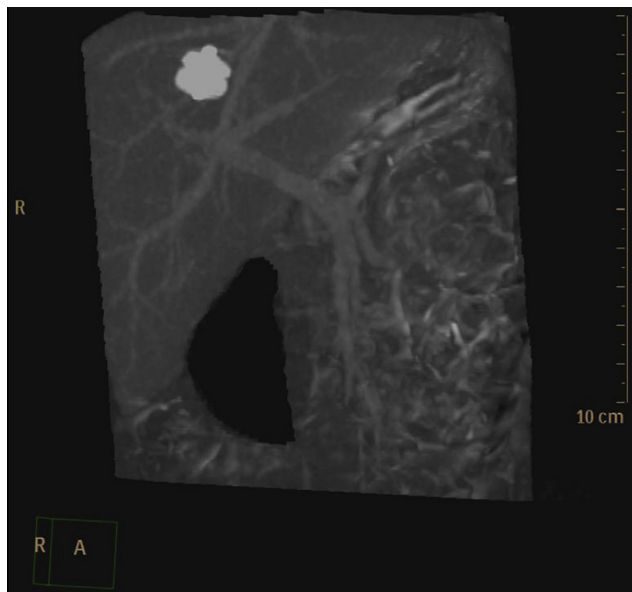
Follow-up CTA at 6 months postoperation demonstrating revascularization of portal venous system.
